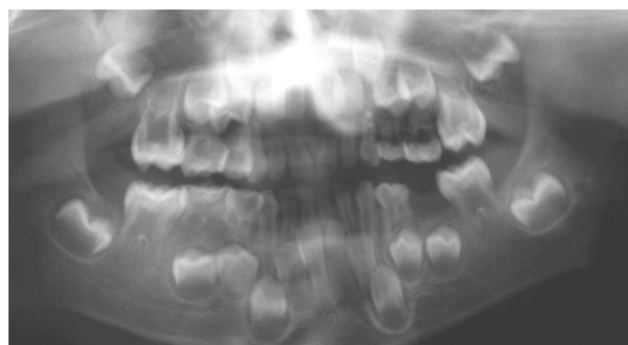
Panoramic radiograph of a 5-year-old boy suffering from XLHR. Although no dental decay was obvious, teeth 54, 84 and 63 were associated with sinus tracts with discharge of pus
